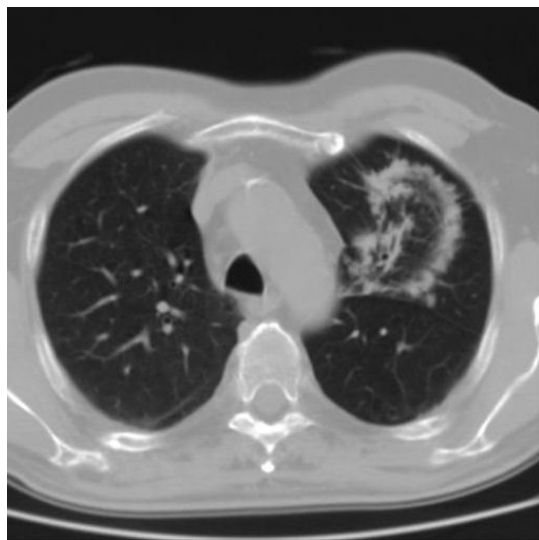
Computed tomography scan of the chest, abdomen and brain revealed infiltration of left lung parenchyma.
